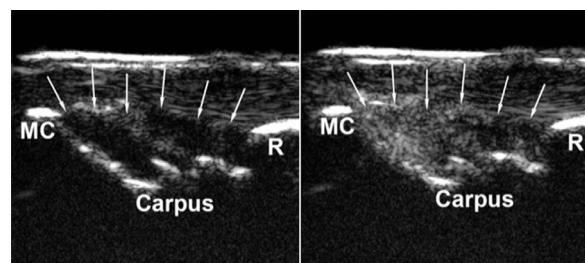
Contrast-enhanced ultrasound pannus hyperperfusion in a patient with clinically active rheumatoid arthritis. Longitudinal dorsal wrist with high-grade enhancement in the synovial proliferation (arrows) after ultrasound contrast agent injection (right side) indicating active joint inflammation. MC = metacarpus; R = radius. Informed patient consent for publication available.
